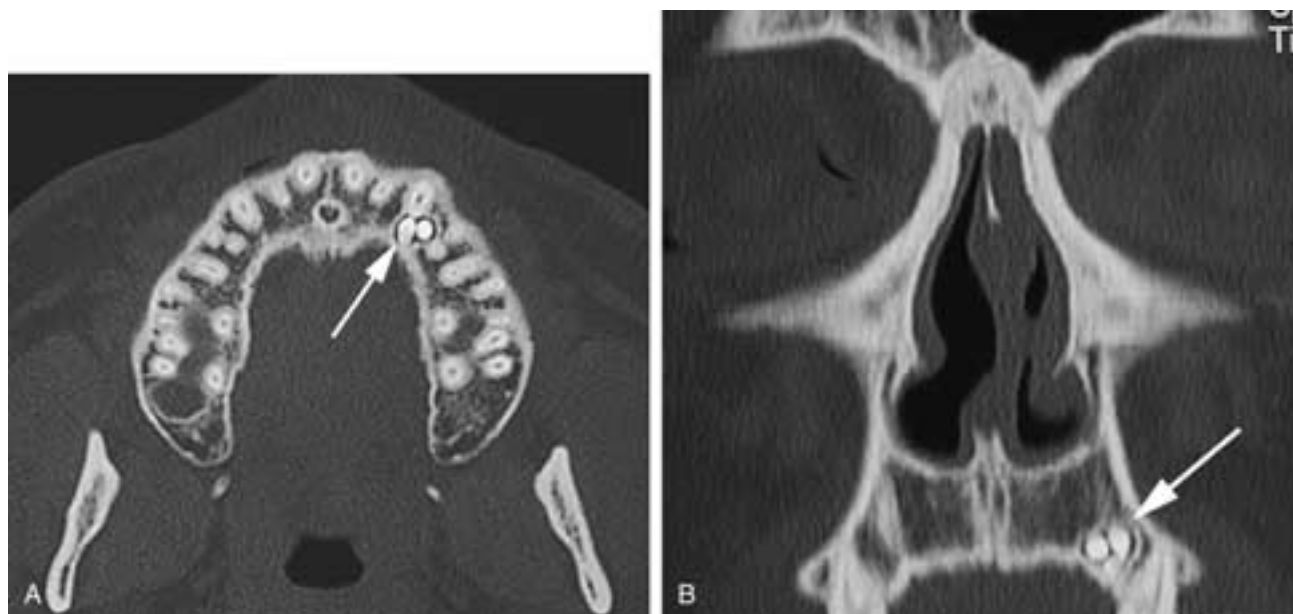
Compound odontoma. CT scan. A, Axial image shows small structures containing both enamel and dentine apparently forming small dental units (*arrow*). B, Coronal CT showing a small compound odontoma (*arrow*).
